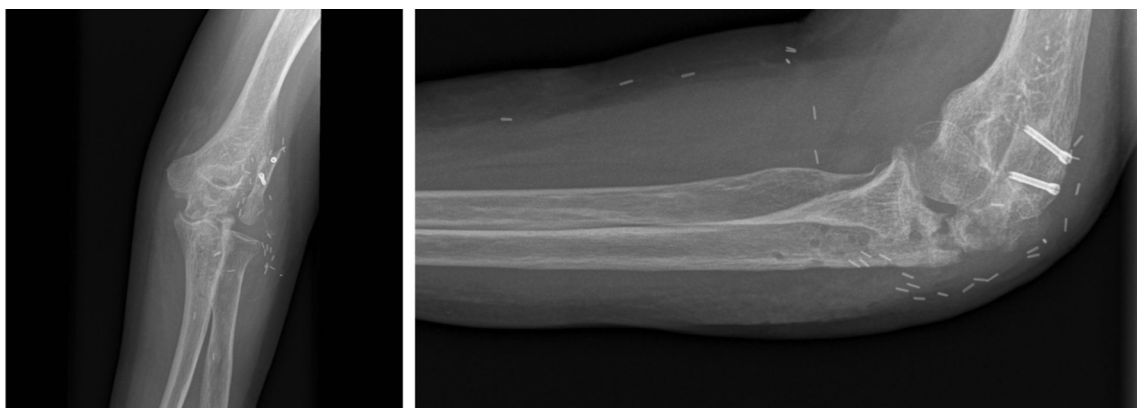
AP and lateral view of radiographs showing the complete integration of the flap after 28 months of follow up.
